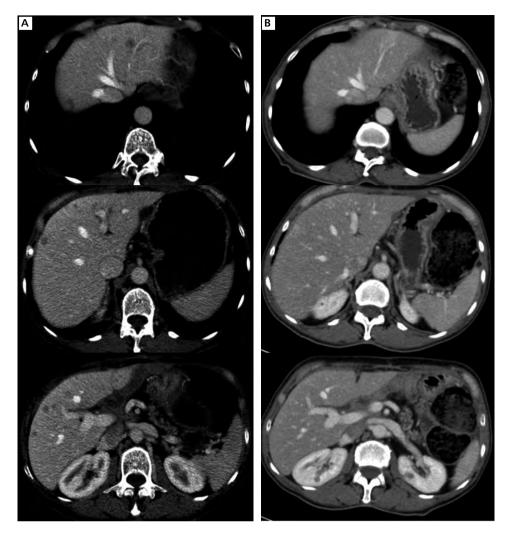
A. Computed tomography, 06.06.2017: numerous metastases in the liver; B. CT, 03.10.2017: complete regression
